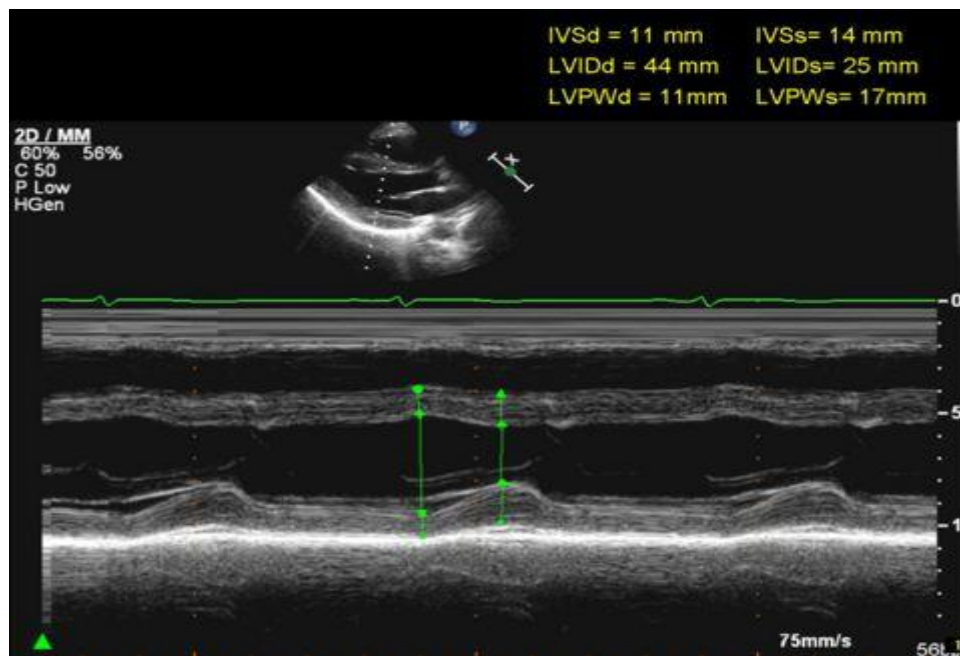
2D Echocardiogram wall measurements
